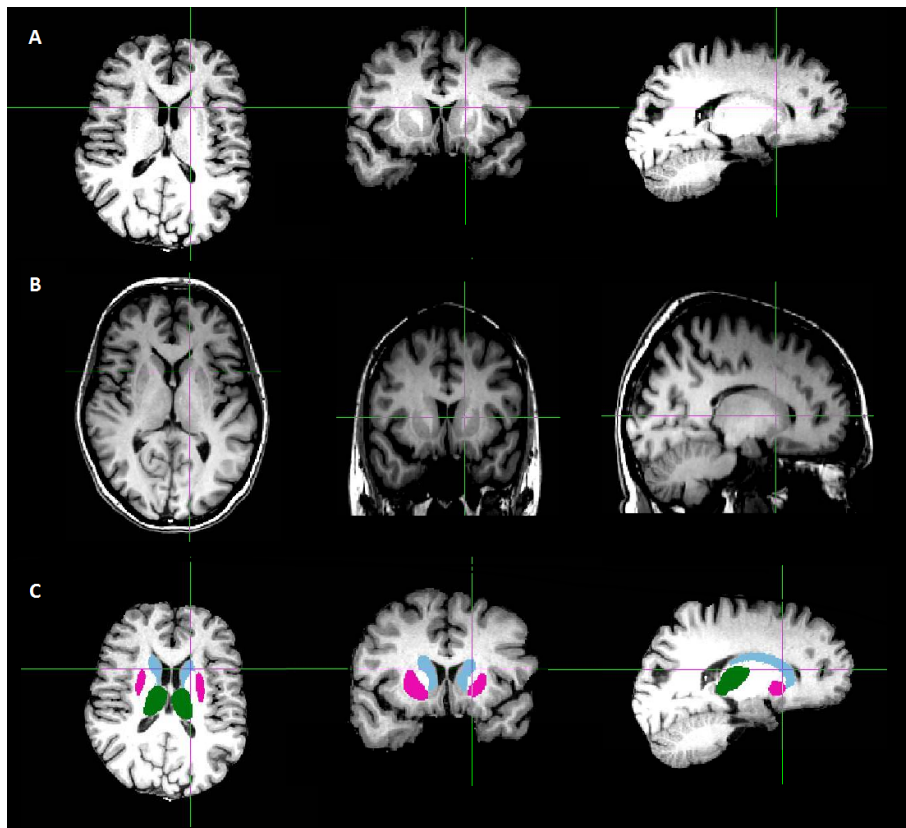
A - MRI image with a contrast enhancement for better distinction of BG structures; B - T1-MRI image after two-stage affine registration to the MNI space; C - Fusion of the MRI enhancement images with the caudate nucleus (light blue), thalamus (green) and putamen (pink) masks estimated with FIRST from Patient 1.
